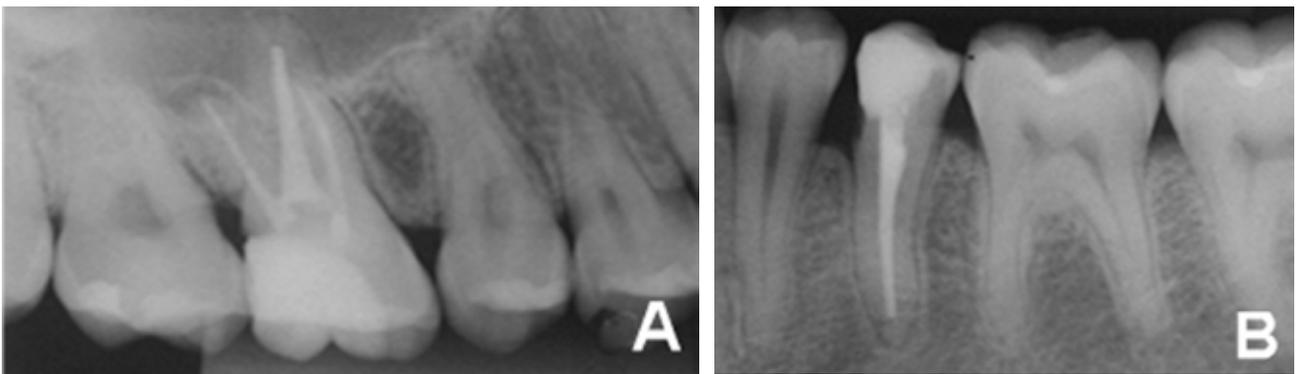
Radiographic two years follow-up of tooth 16 (A) and 35 (B).
